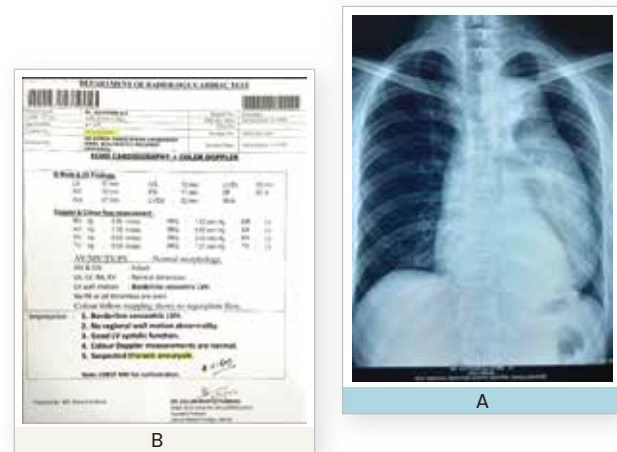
A) Chest x-ray, B) Echocardiography of the patient
